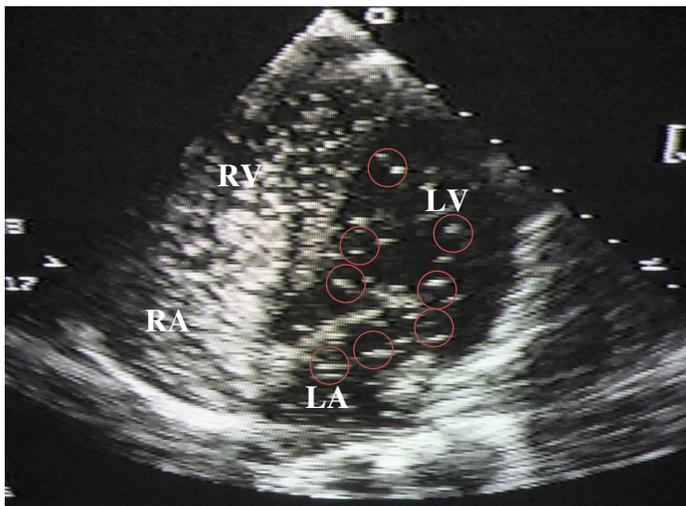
2 and 2.3 were obtained from a 24 year-old male ( $\% \text{predicted VO}_2\text{max} = 160$ ) and the images were taken from an apical 4-chamber view. The echocardiogram images taken for all 9 stages on all 10 subjects under both experimental conditions were clear and a decision of intrapulmonary shunt presence for each stage was able to be made. Figure 2.1 depicts an echocardiogram of the subject sitting upright on the Velotron; the image is taken after at least 3 cardiac cycles following appearance of bubbles in the right heart. At this point, both the right atrium and right ventricle are densely opacified with contrast bubbles, while the left atrium and left ventricle remain free of bubbles – this indicates the trapping of bubbles at the pulmonary capillaries and thus, no indication of intrapulmonary shunt. Figure 2.2 depicts an echocardiogram the subject cycling upright at 125 W; the image is taken at least 3 cardiac cycles following appearance of bubbles in the right heart. Again, the right side of the heart is full of contrast bubbles but there are clearly bubbles present in the left side of the heart which indicates the presence of intrapulmonary shunting. Figure 2.3 depicts an echocardiogram of the subject cycling at 300 W; at least 3 cardiac cycles following appearance of bubbles in the right heart, the right heart is full of contrast bubbles while the left heart has a cloud of contrast bubbles as well – this shows a prominent presence of intrapulmonary shunting. Although we are unable to quantify the shunt fraction, the degree of contrast bubble presence in the left side of the heart between figure 2.1, 2.2, and 2.3 can qualitatively provide some insight on the likelihood of the increase in intrapulmonary shunt presence as workload increases.
